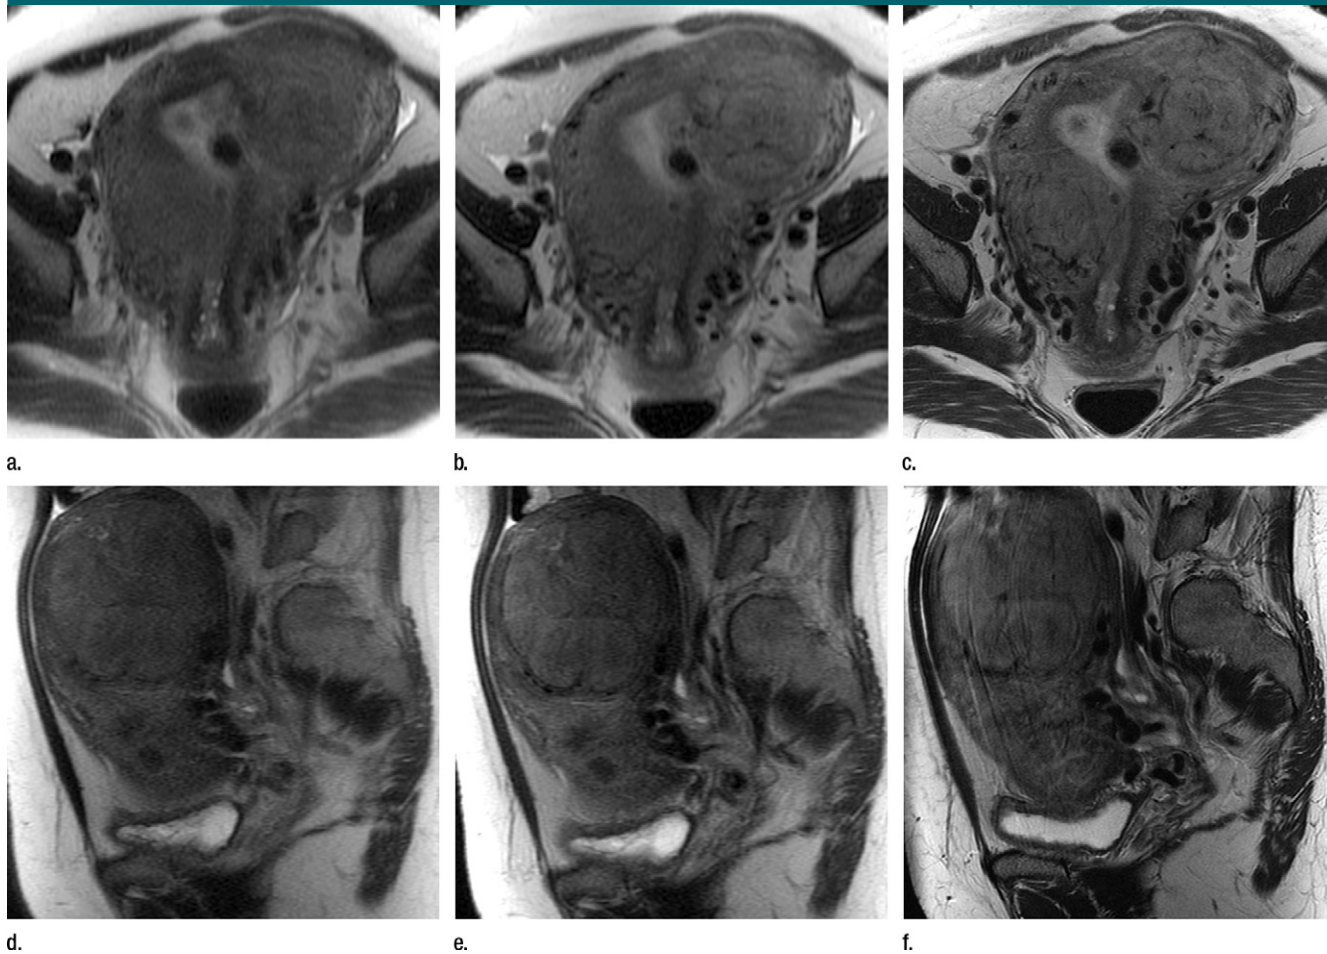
(a–c) Coronal oblique and (d–f) sagittal T2-weighted MR images obtained in a 55-year-old woman with a large, pathologically proven intramural leiomyoma demonstrate atypical intermediate signal intensity by using conventional SSFSE (a, d), vrfSSFSE (b, e), and FSE (c, f) imaging. A small, typically appearing intramural leiomyoma is medially adjacent, and an additional, typically appearing intramural leiomyoma along the right uterine wall is partially included in the plane of imaging. Images were cropped to 20 cm; the SSFSE and vrfSSFSE images were acquired with a 42-cm (coronal oblique) or 30-cm (sagittal) field of view, and the FSE images were acquired with a 22-cm field of view. Note the improved black-blood appearance in vessels with vrfSSFSE imaging compared with conventional SSFSE imaging, owing to its increased sensitivity to flow-related signal loss. Artifacts on the FSE images that are projecting over the uterus are from respiratory motion.
